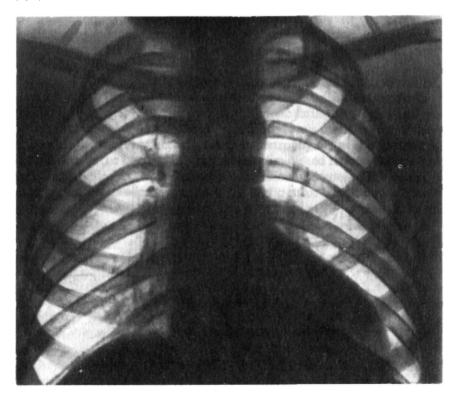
X-ray in aortic incompetence. The heart's configuration is aortic; the left ventricle is dilated and hypertrophied, the ascending aorta is dilated.
